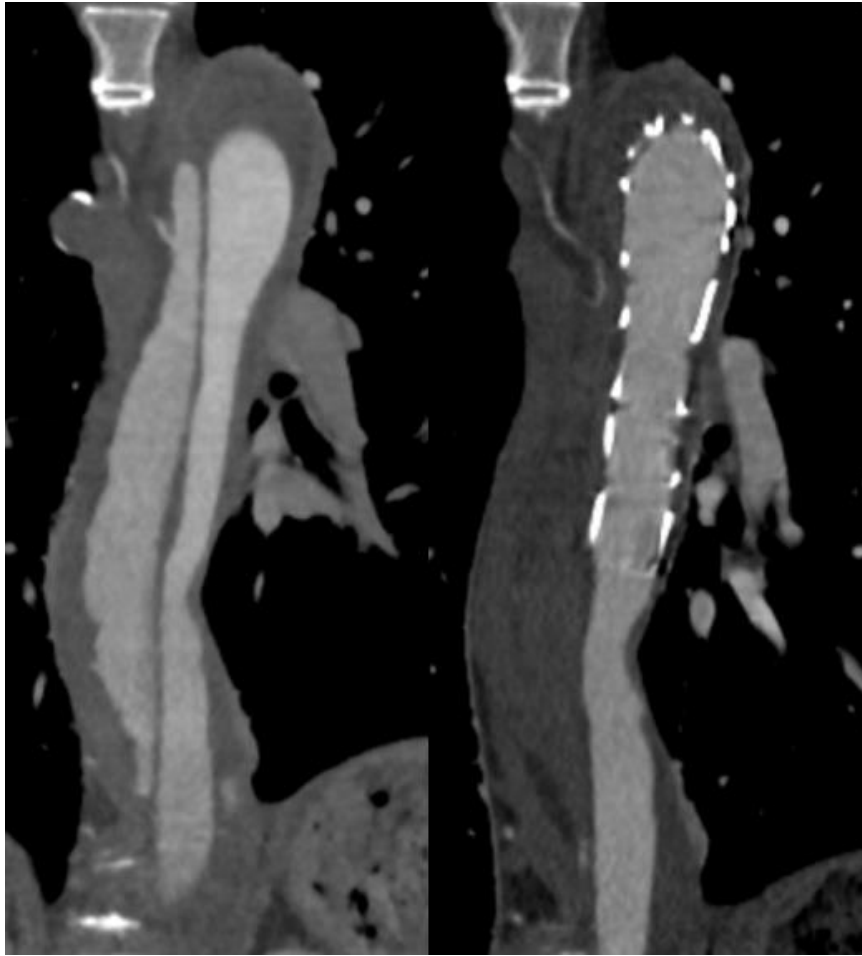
Coronal View of patient's CTA image before (left) and after (right) TEVAR treatment of AD..
